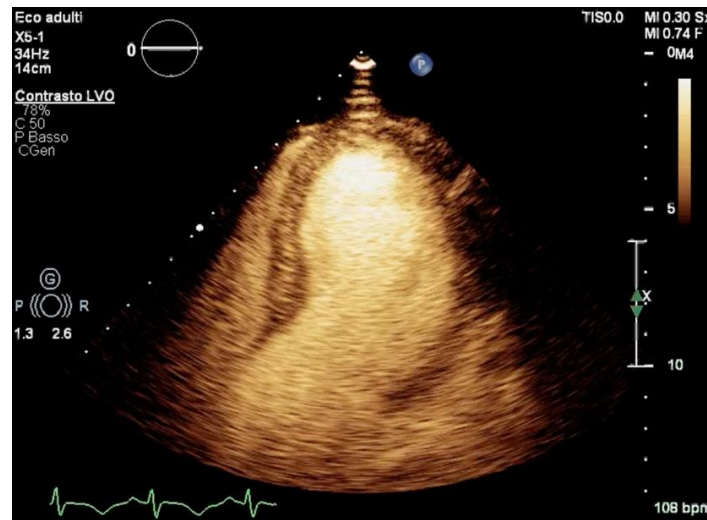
Echocardiogram with contrast agent showing the absence of thrombotic apposition in cardiac apex
